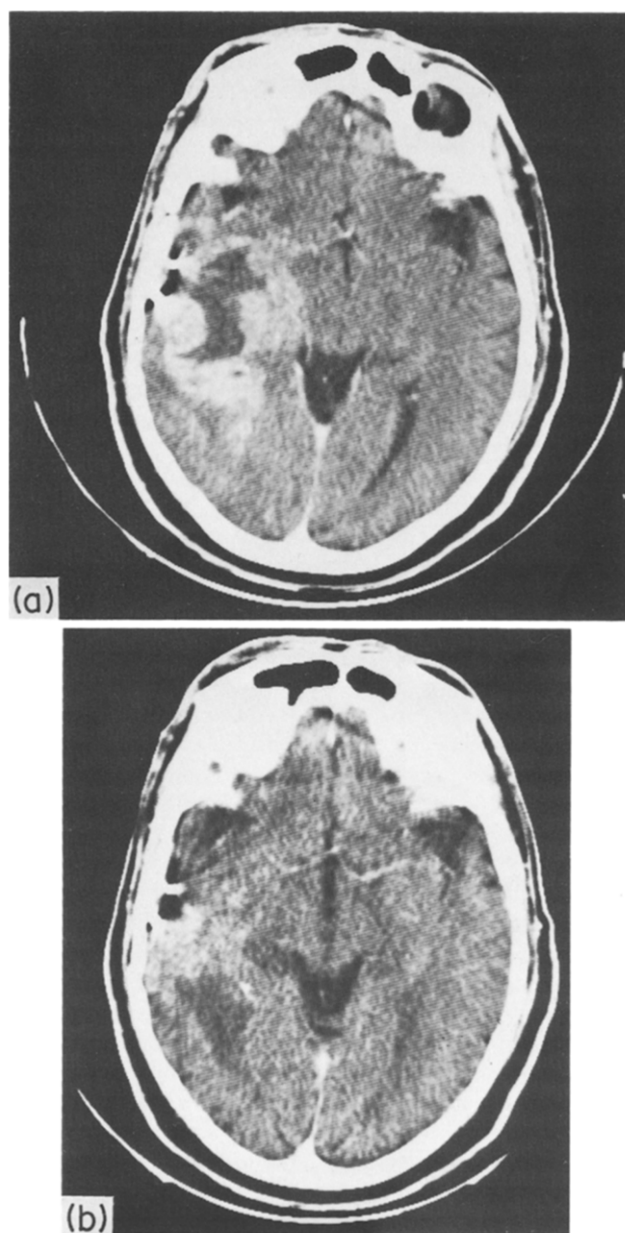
(a) Recurrence of right temporoparietal glioblastoma with prior surgery and radiotherapy (disease-free survival: 14 months) and (b) same patient with partial response after 3 infusions of fotemustine (CT 5 months after beginning of treatment and without steroids). This patient was not treated with maintenance schedule for personal reasons.
